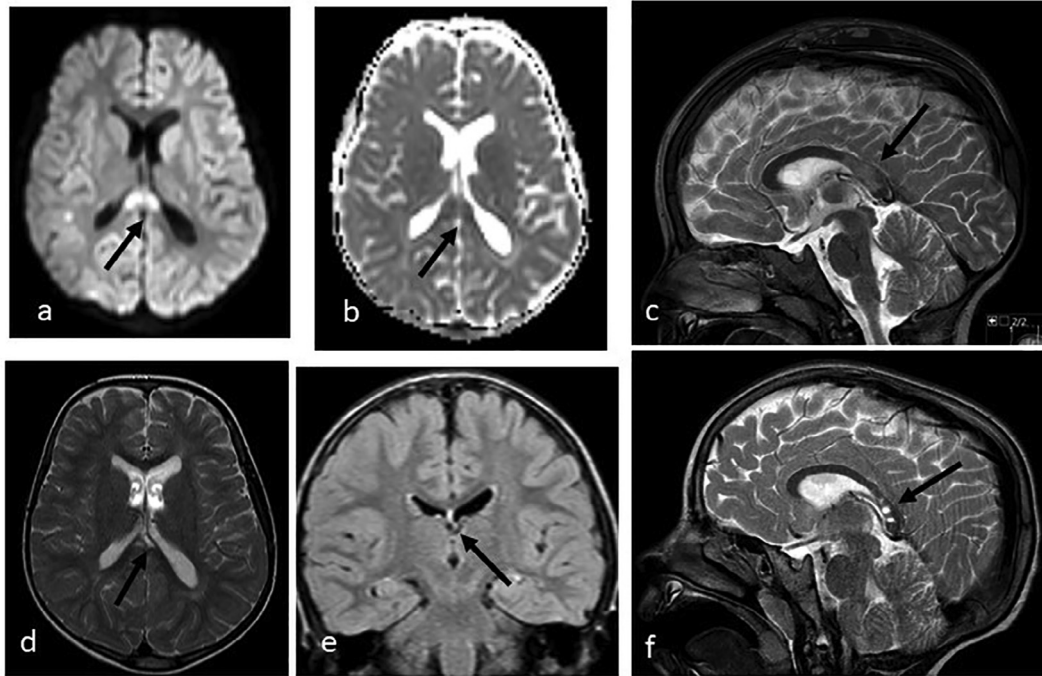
Diffuse axonal injury due to television fall over in a 3-year-old child showing splenic diffusion restriction irregularly shaped (a,b,c), 2 months later cystic sequela changes is evident in the same area on T2 and FLAIR weighted MRI (d,e,f).
